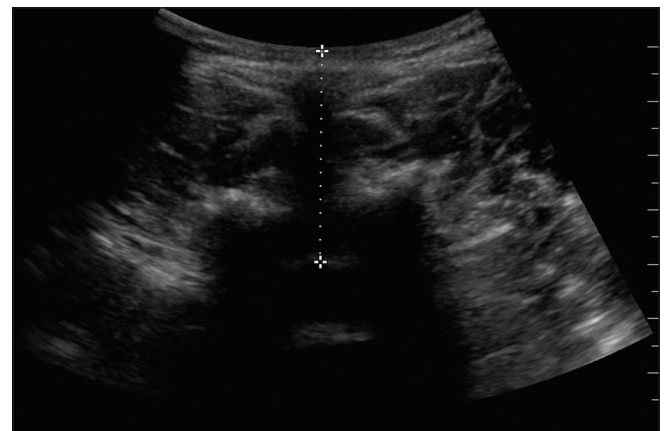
For skin to subarachnoid space depth using ultrasound, the distance from skin to the anterior part of the ligamentum flavum-dura mater complex was measured on a transverse scan at L3–L4 interspace
